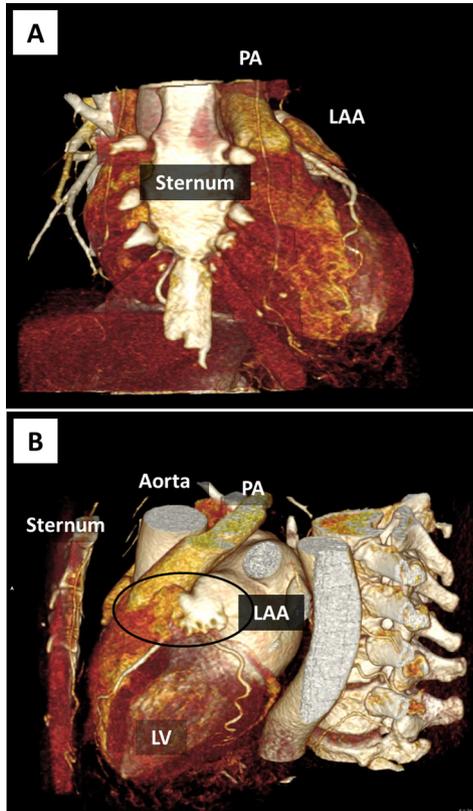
CT imaging of favorable LAA anatomy. (A) Anteroposterior view of the chest with the sternum in the foreground. The LAA is lateral to the main pulmonary artery (PA). This LAA anatomy is typically favorable for the LARIAT procedure. (B) Corresponding lateral view with the LAA in the foreground. LV, Left ventricle.
